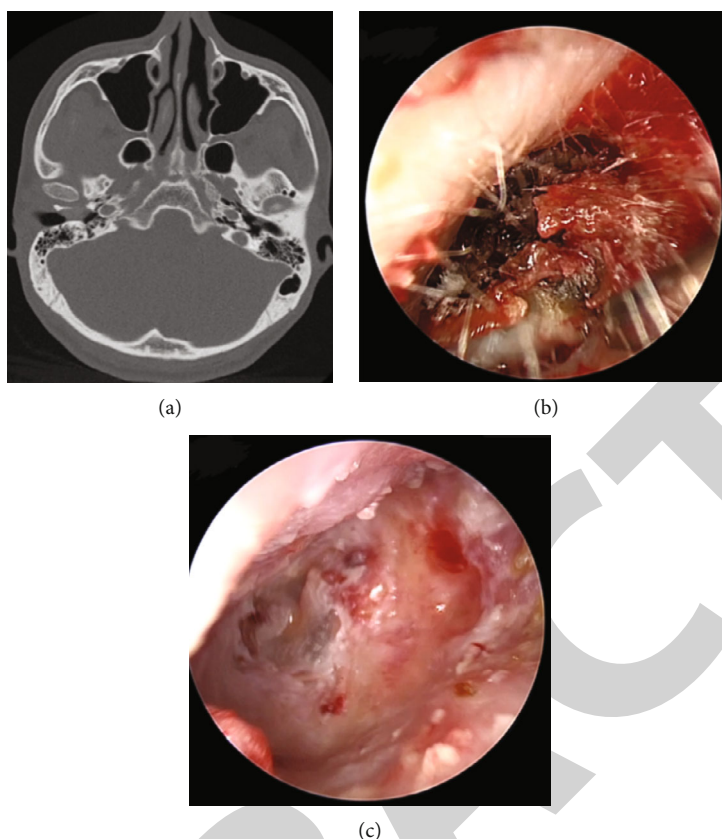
Excision of external auditory canal cholesteatoma in patients with EACC stage II. Note: (a) CT in patients with EACC stage II revealed destruction of the bone wall of the external auditory canal and no involvement of the middle ear; (b) cerumen and white cholesteatoma epithelium in the external auditory canal were observed under an otoendoscope; (c) ear endoscopy after external auditory canal cholesteatoma removal surgery in patients shows intact and thin tympanic membrane and enlargement of the bone wall of the external auditory canal.
